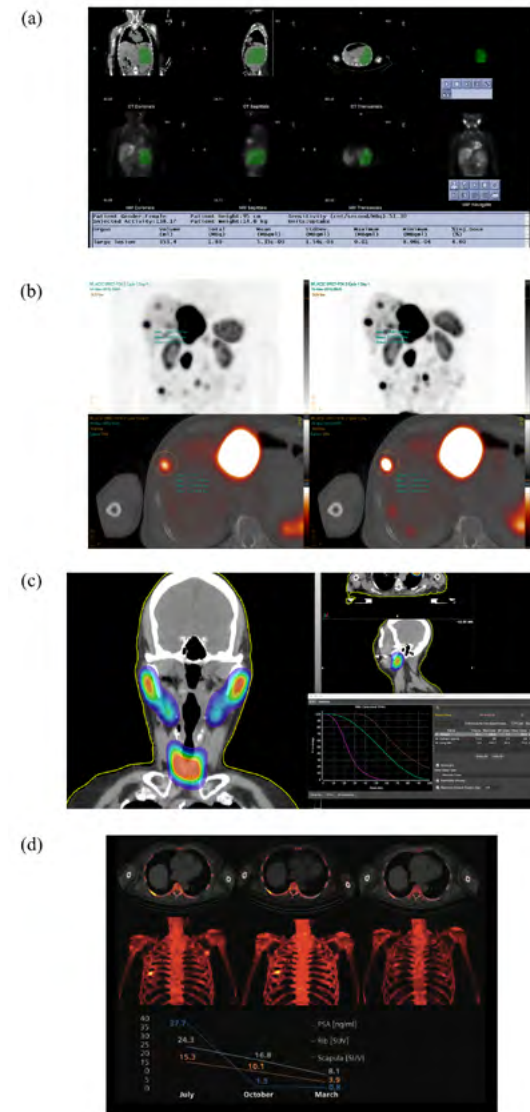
(a) An Iodine-123 mIBG SPECT/CT study showing SUV and tumour volume metrics using GE Q.Metrix. (b) Day 0 and Day 1 Lu-177 DOTATATE SUV SPECT images, quantitative reconstruction performed with Hybrid Recon from Hermes Medical Solutions, images displayed in Affinity Viewer (Image courtesy of Hermes Medical Solutions). (c) Dose contours and dose volume histograms following a radionuclide therapy using MIM Sureplan (Image courtesy of MIM Software Inc.) (d) A longitudinal Tc-99m MDP series showing the change in SUV in Rib and Scapula bone lesions using xSPECT Quant (Image courtesy of Siemens Healthineers).
